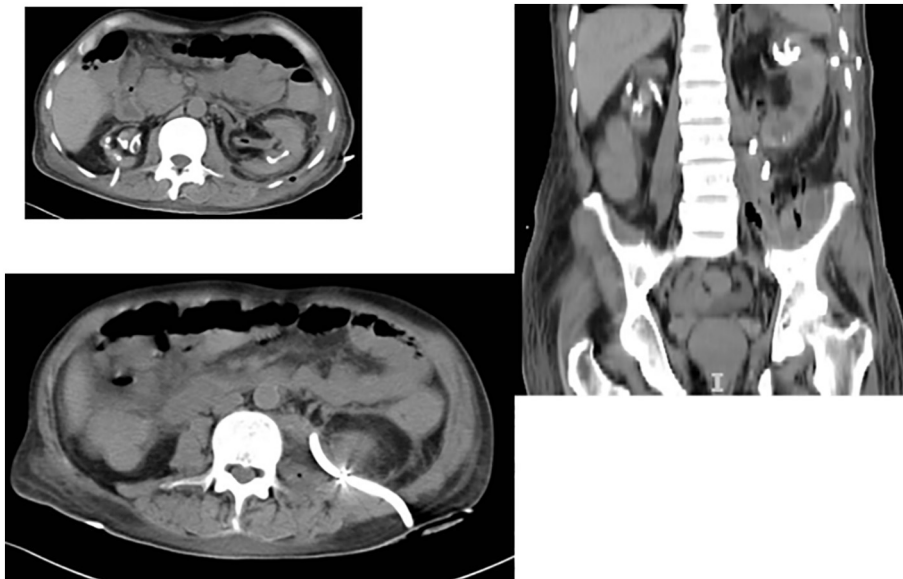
CT images. Resolution of the EP and psoas abscess after drainage.
